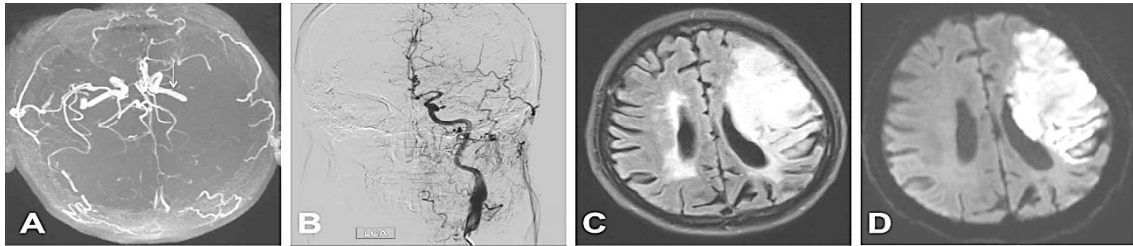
A male patient (45 years old) with right limb weakness for three days. A: arrow denotes M1 occlusion on MRA maximum intensity projection (MIP) images. B: abundant collateral vessel can be seen from angiography. C: arrows on FLAIR show prominent HV. Both P-WMHs and d-WMHs score are 0. D: acute stroke ASPECT score is 9 with only one area affected.
